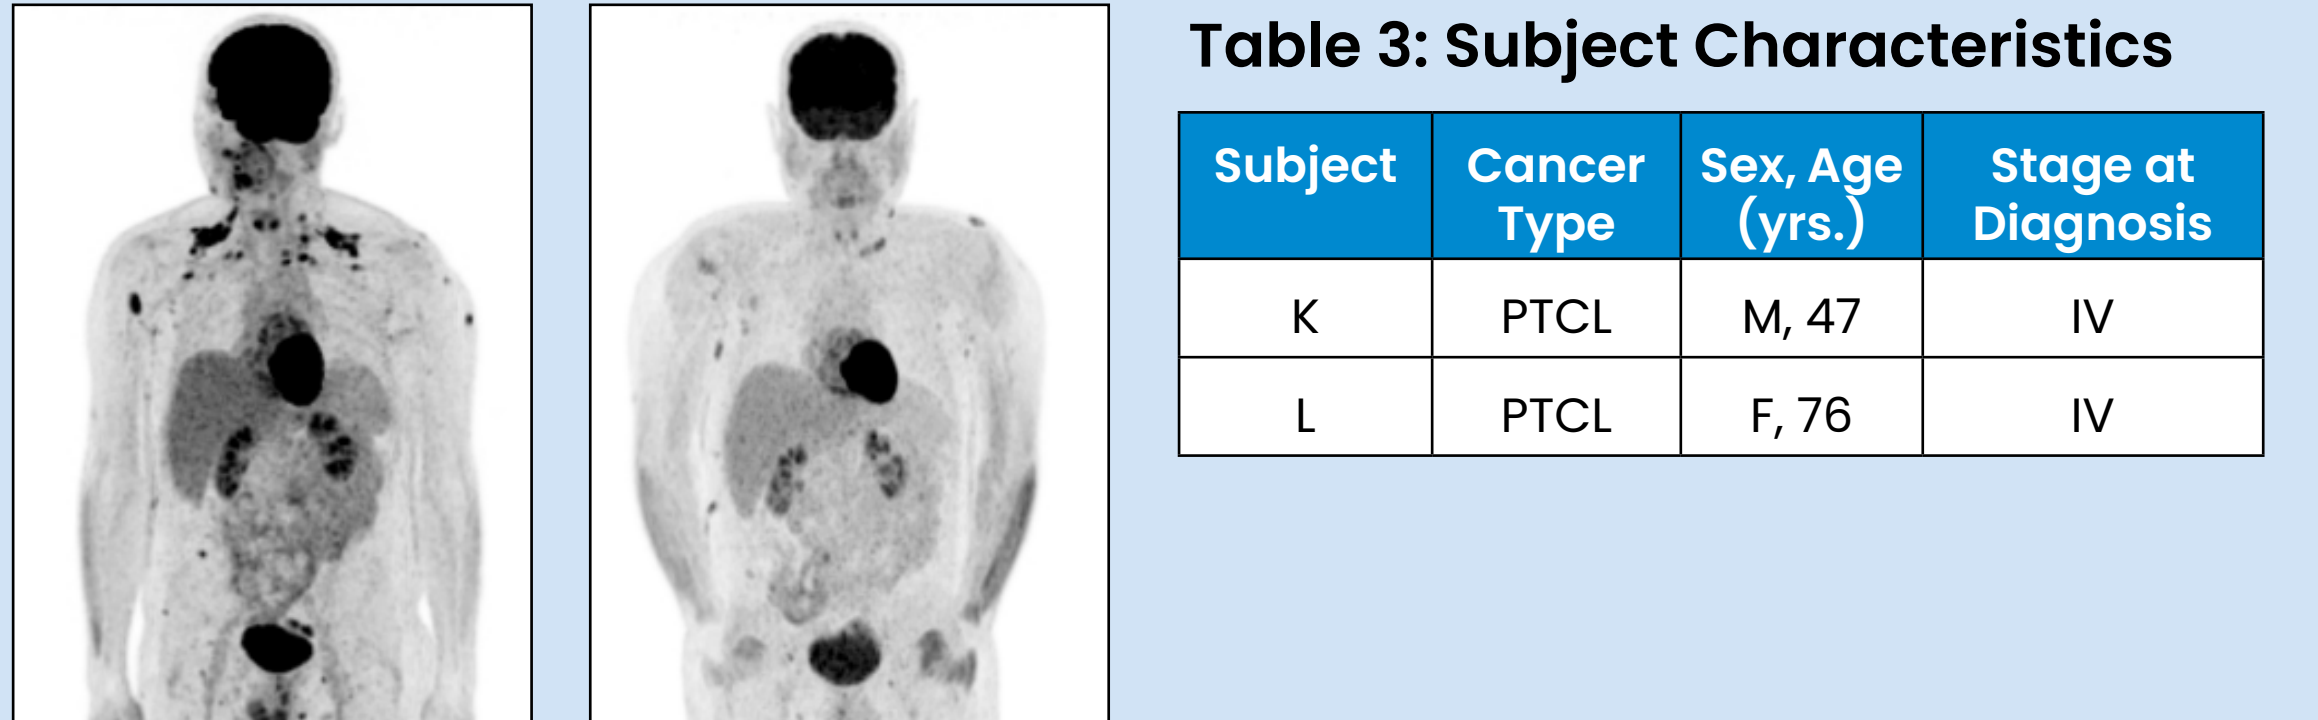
FDG-PET assessment at baseline (left) compared to week 9 (right)
